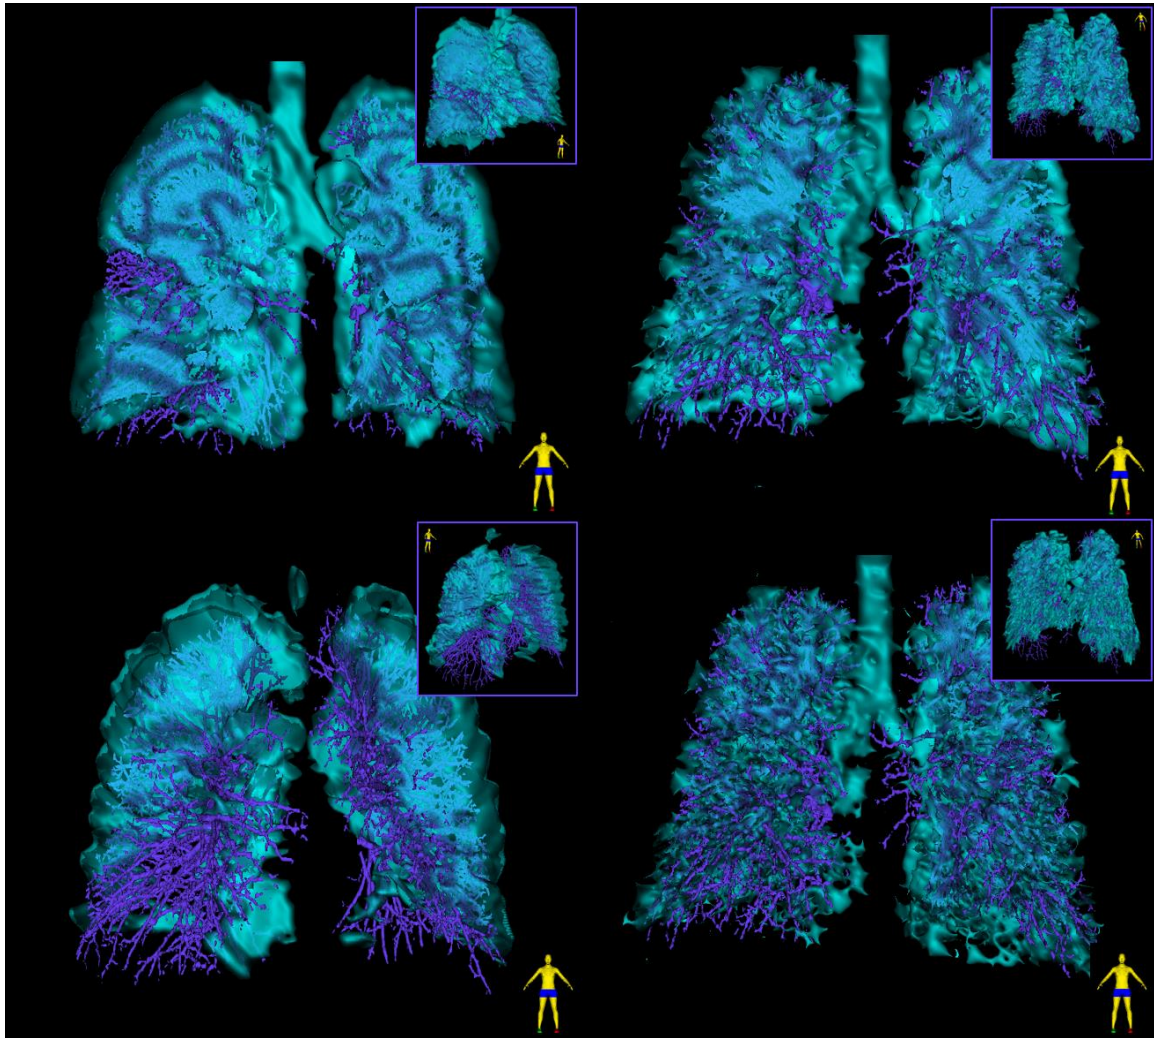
3D model of ^3He MRI ventilation and CT vessels for four representative participants.
